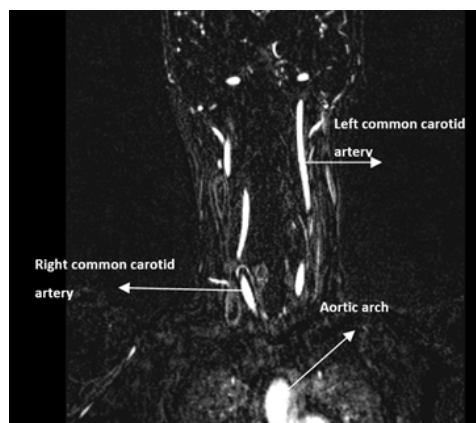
Subtracted image. Adapted from: (private MRI clinic, 2018).
